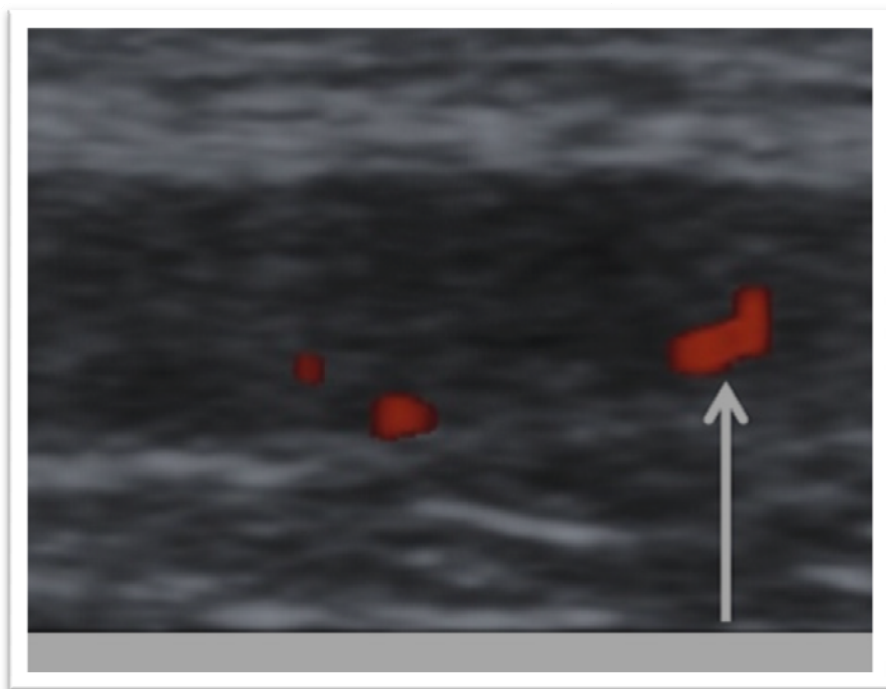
Colour Doppler showing vascularity in ulnar nerve in a patient with type 1 reaction
